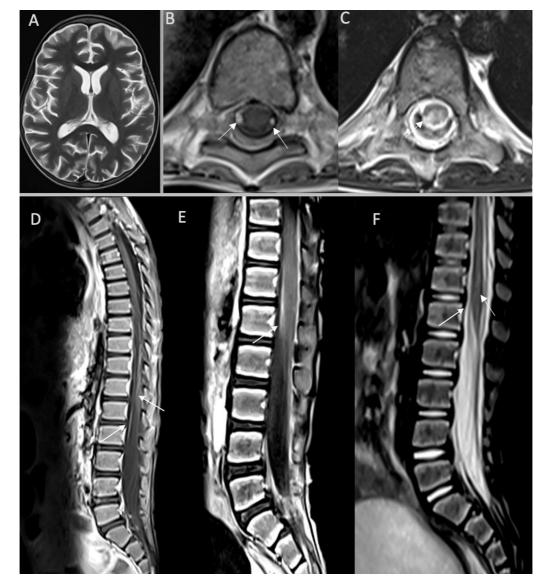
Brain and spinal magnetic resonance imaging of case 1. Axial T2-weighted (T2W) brain image shows cerebral atrophy (A). Postcontrast axial (B) and sagittal (D, E) T1W images pial and cauda equina contrast enhancement (arrows). Axial (C) and sagittal (F) T2W spinal images show hyperintense cord lesion consistent with myelitis (arrows).
